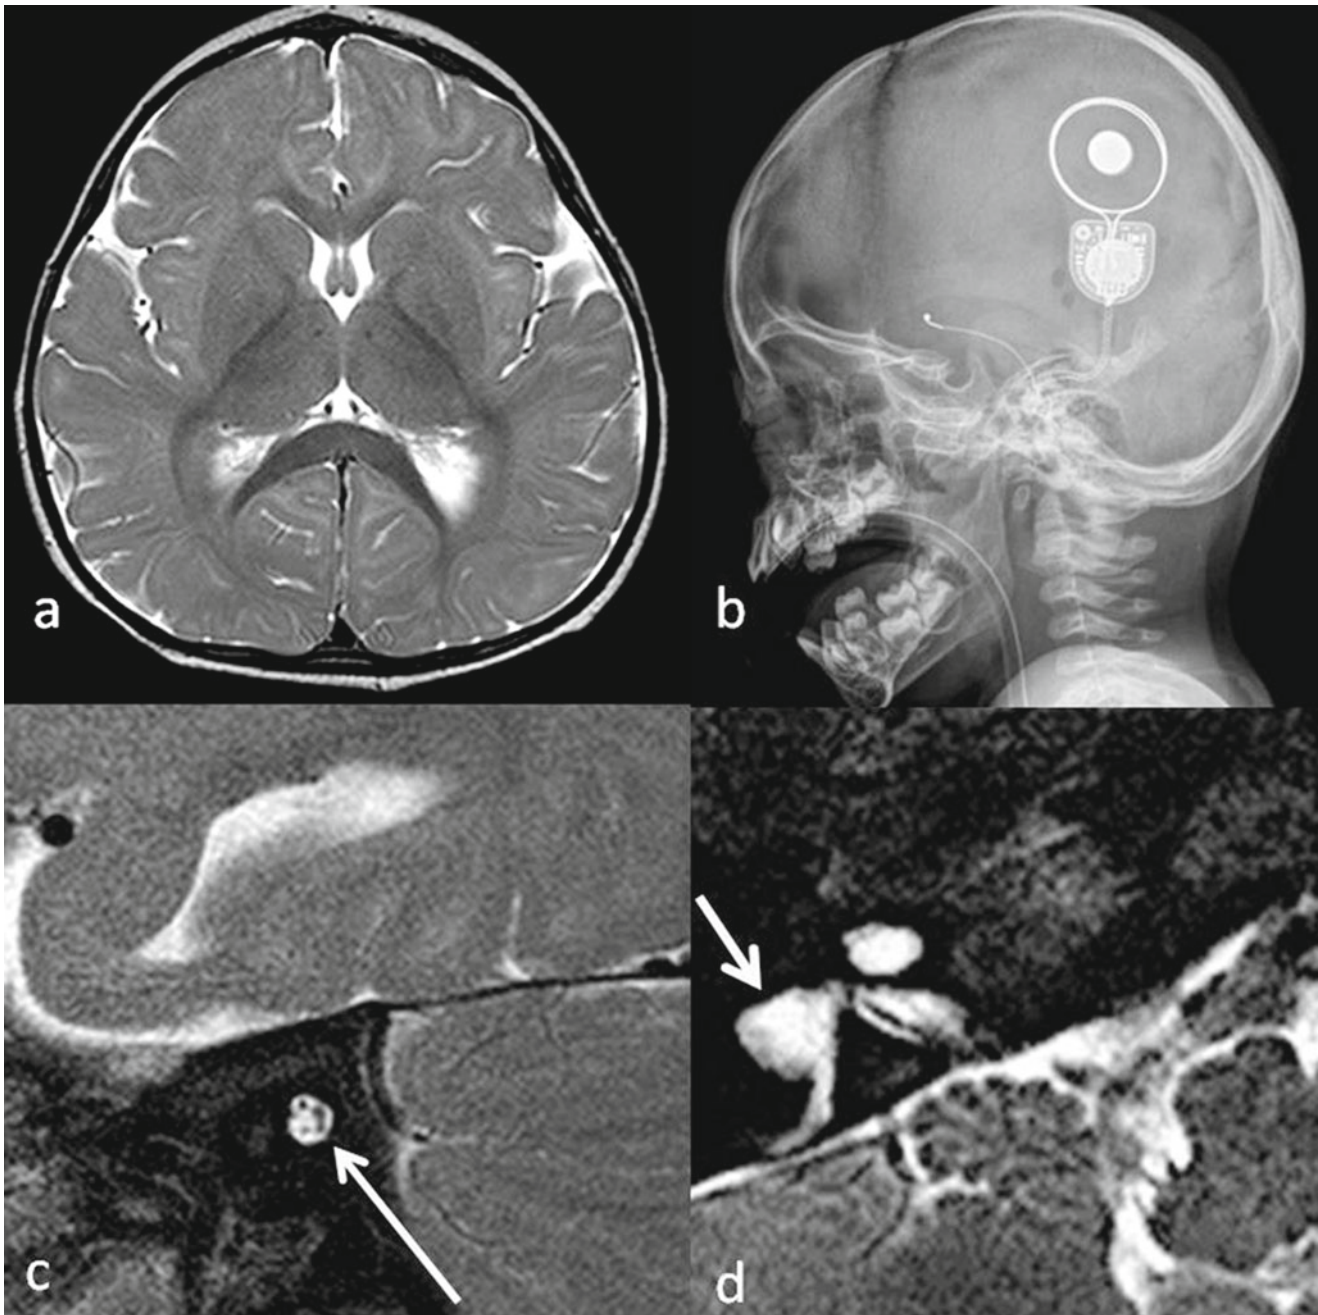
Imaging of child with primary microcephaly. (a) Axial T2 MR image with disproportionately small brain and cerebral cortex; (b) Lateral radiograph demonstrates more vertical positioning of receiver-stimulator. High resolution 3D MR of temporal bone with (c) Sagittal
